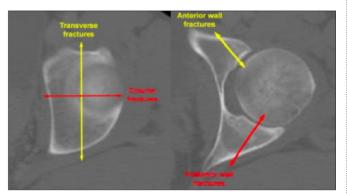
CT scan acetabulum demonstrating fracture lines.
